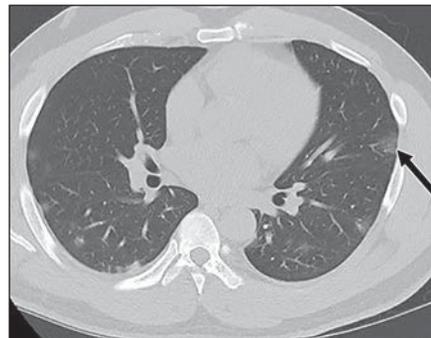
40-year-old man with abdominal pain and gastrointestinal symptoms. Axial CT of abdomen and pelvis shows multifocal subpleural ground-glass opacities (*arrow*) in visualized lungs. This nonspecific finding may be result of atypical infection such as coronavirus disease (COVID-19) pneumonia.
